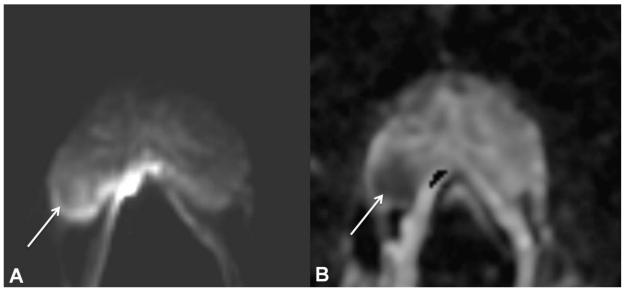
(A-DWI, B-ADC) DWI PIRADS score 4 - Focal area of reduced ADC but iso-intense SI on high b-value image.
